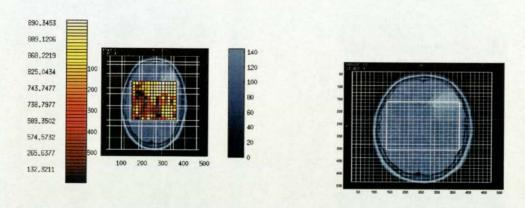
Gadolinium-enhanced MRI scan for an oligodendroglioma grade 2 patient with and without NeuroScale distances mapped on top (Euclidean distance).
